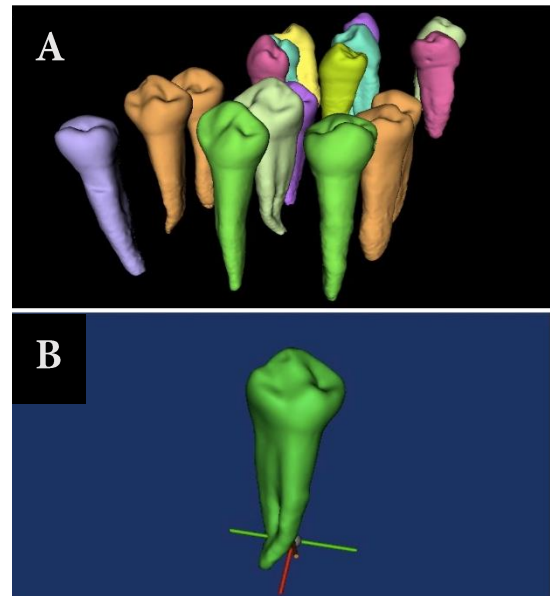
A) Tridimensional models built from the CBCT images, on InVesalius; B) Mimics
